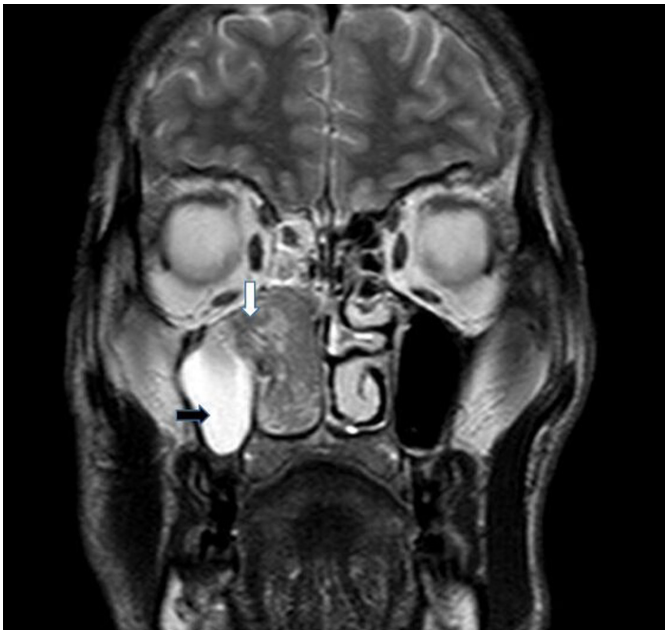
T2 weighted axial magnetic resonance imaging section
